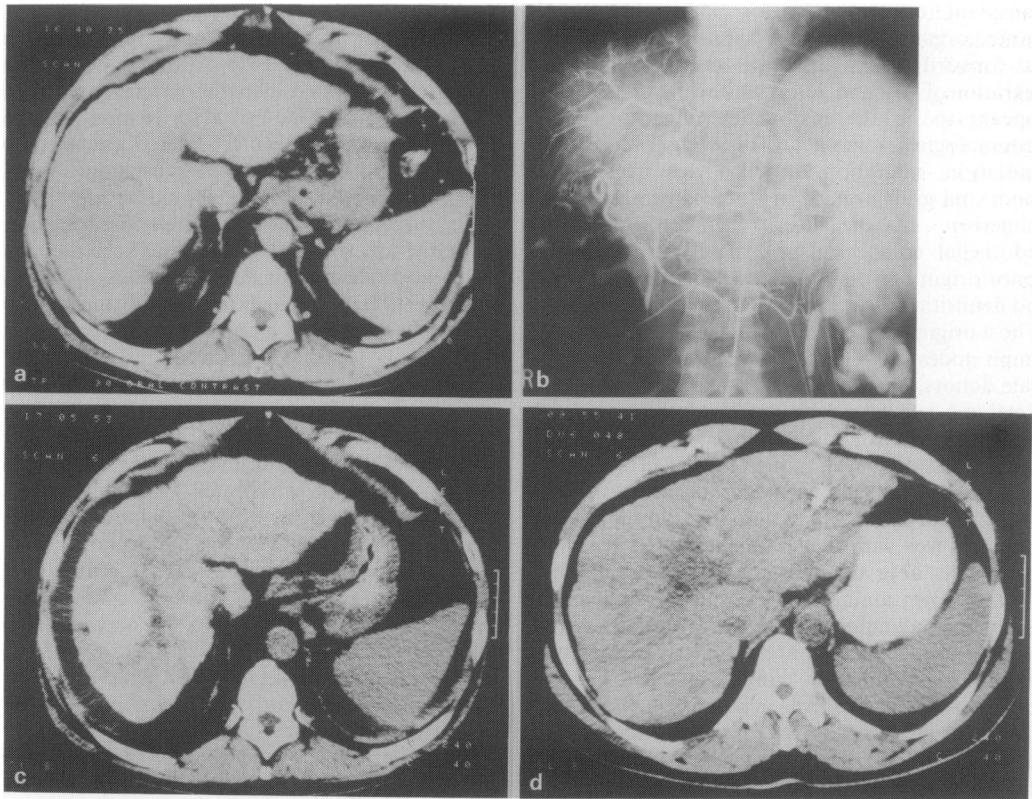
(a) CT scan of a patient with HBV-related hepatoma, tumour in R lobe. (b) Hepatic angiogram in the same patient when lipiodol, doxorubicin and gelfoam embolization undertaken. Tumour circulation can be seen. (c) CT scan 3 days after the procedure with retained lipiodol. (d) CT scan 4 months after final embolization, no tumour visible.
